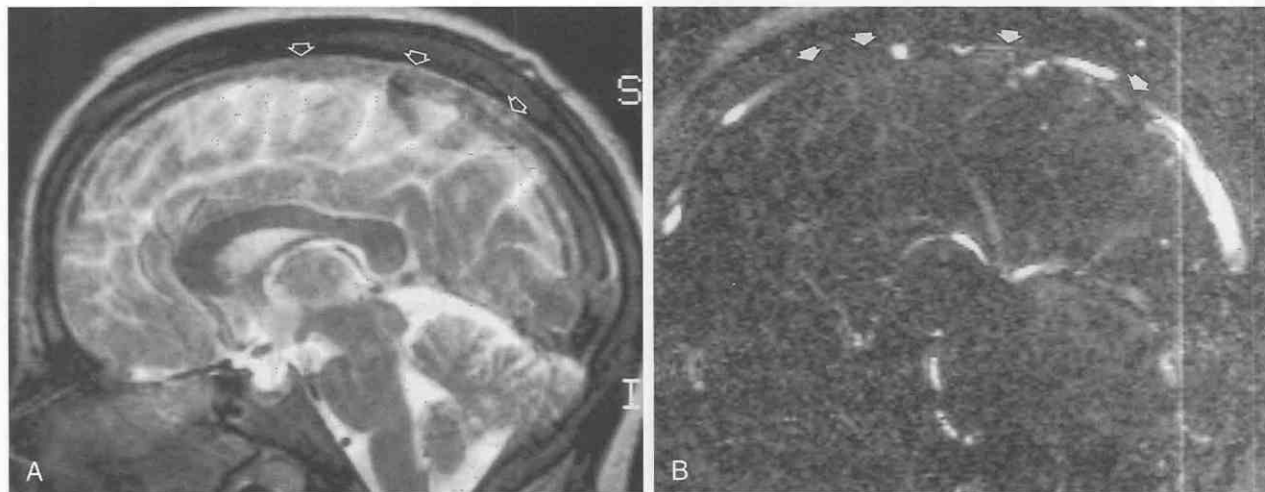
Superior sagittal sinus thrombosis. *A*, T2-weighted sagittal MR image shows increased signal in the superior sagittal sinus (*open arrows*). *B*, Partition image from a phase-contrast MR venogram study (VENC = 5 cm/second) shows regions of absent flow within the superior sagittal sinus (*small arrows*).
